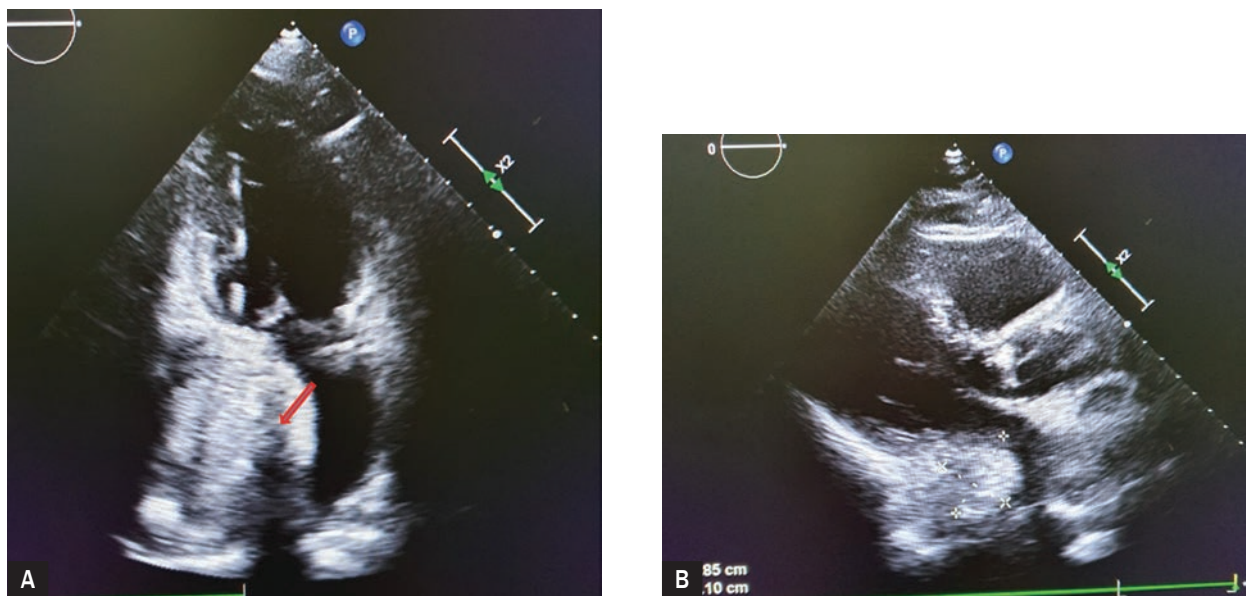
Transthoracic echocardiography: A. Dual-chamber view – a structure compressing the left atrium marked with an arrow; B. Parasternal long-axis view – a structure protruding into the left atrial chamber marked
